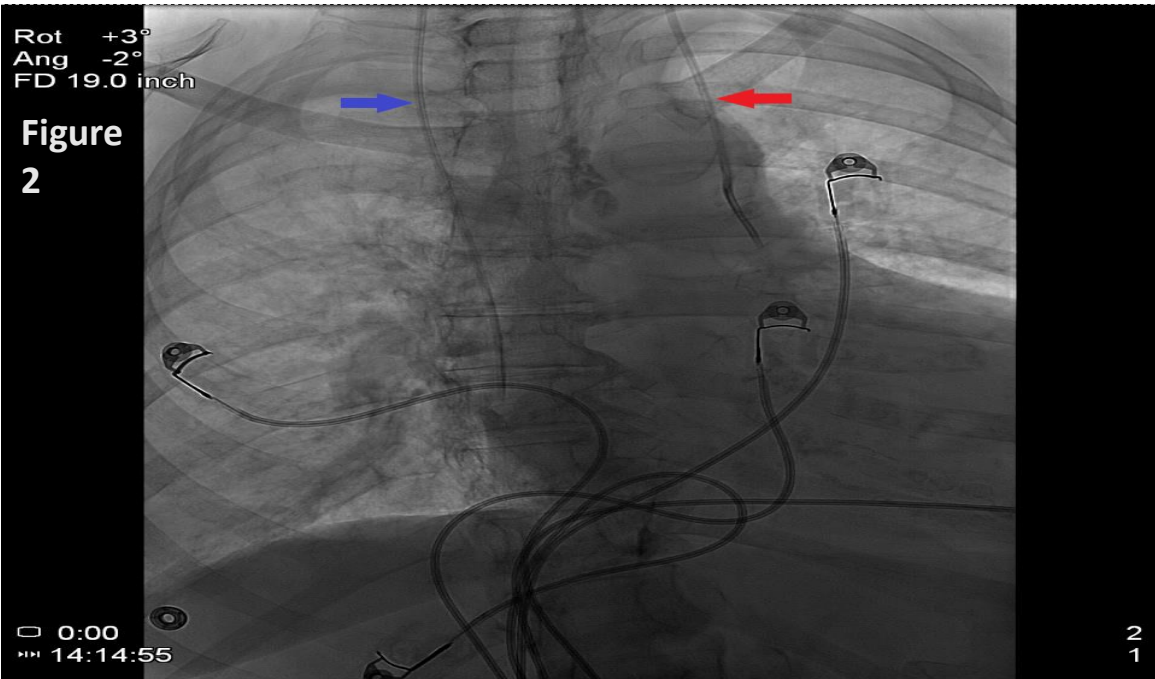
Chest radiograph with right-sided central venous catheter (blue arrow) as well as the malpositioned left-sided catheter in the left internal thoracic vein (red arrow), prior to removal of the latter
